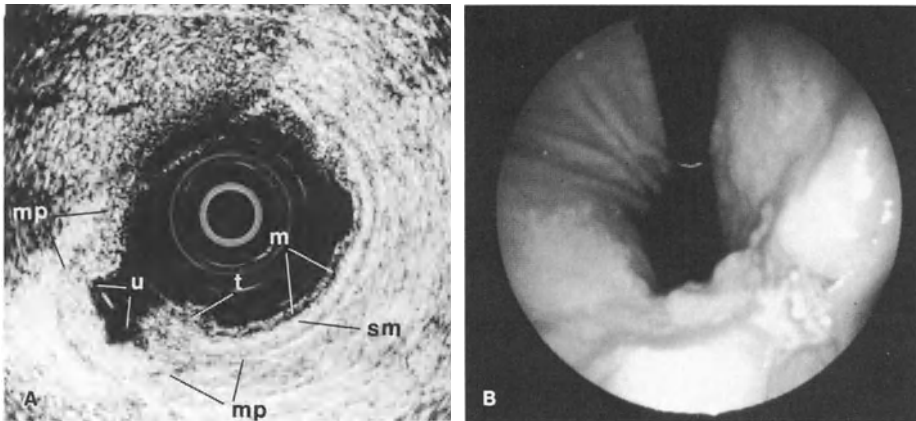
A Endoscopic sonogram showing a circumscribed hypoechoic lesion in the mucosa and submucosa (*t*) adjacent to an ulcer (*u*), with no penetration into the muscularis propria (*mp*). *m*, mucosa; *sm*, submucosa. B Corresponding endoscopic image, showing the ulcerative lesion at the angulus, proven to be an early gastric cancer (type III)
